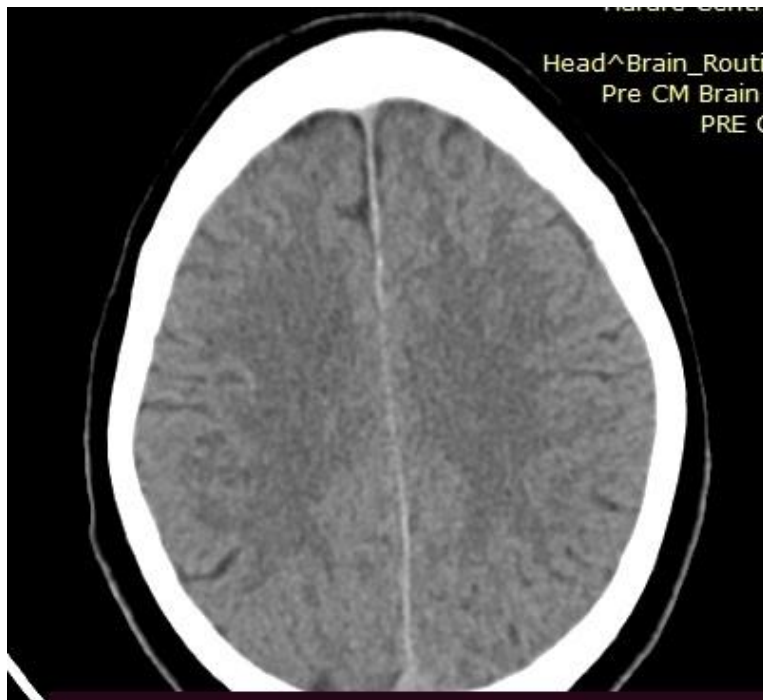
Axial non-contrast enhanced follow up CT scan after 8 weeks
